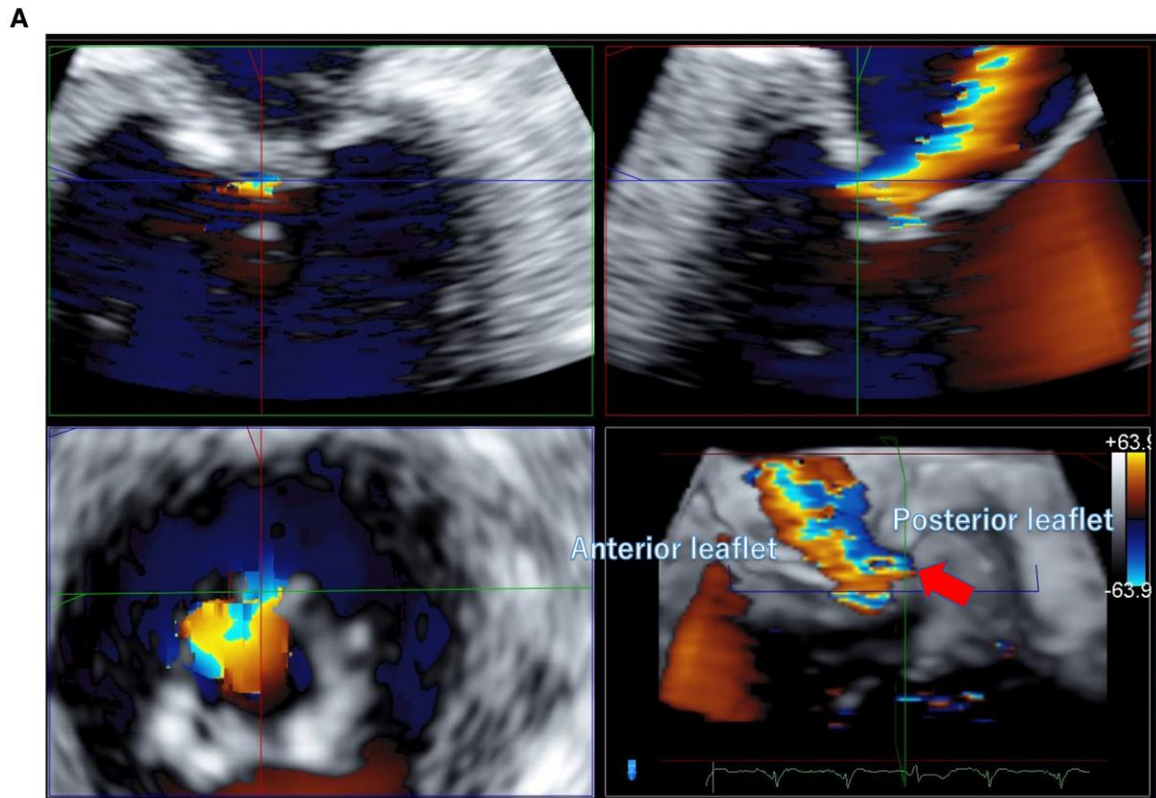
Intraoperative transoesophageal echocardiography after recognizing valve leaflet injury. (A) Delivery of the XTW clip to the previously grasped portion, confirming that the tip of the clip arm was positioned more posteriorly to the leaflet perforation before grasping the leaflets. (B) After fully closing the clip, the mitral regurgitation decreased to mild. (C) Final transoesophageal echocardiography showed mild mitral regurgitation and no stenosis.
